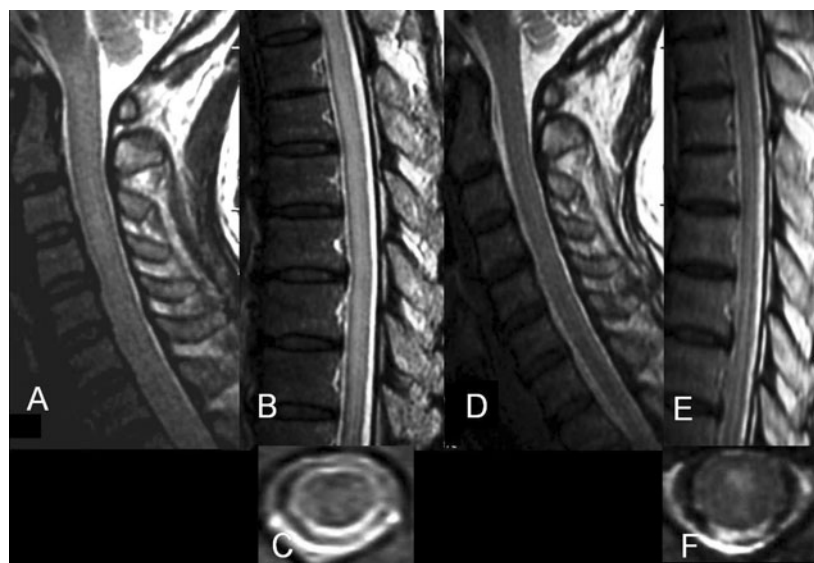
MRI from patient 1, before treatment (A–C), and after treatment (D–F). T2WI (sagittal: A, B, D, E; axial: C, F). Note diffuse spinal cord swelling with high intensity signals from cervical to thoracic cord levels.
